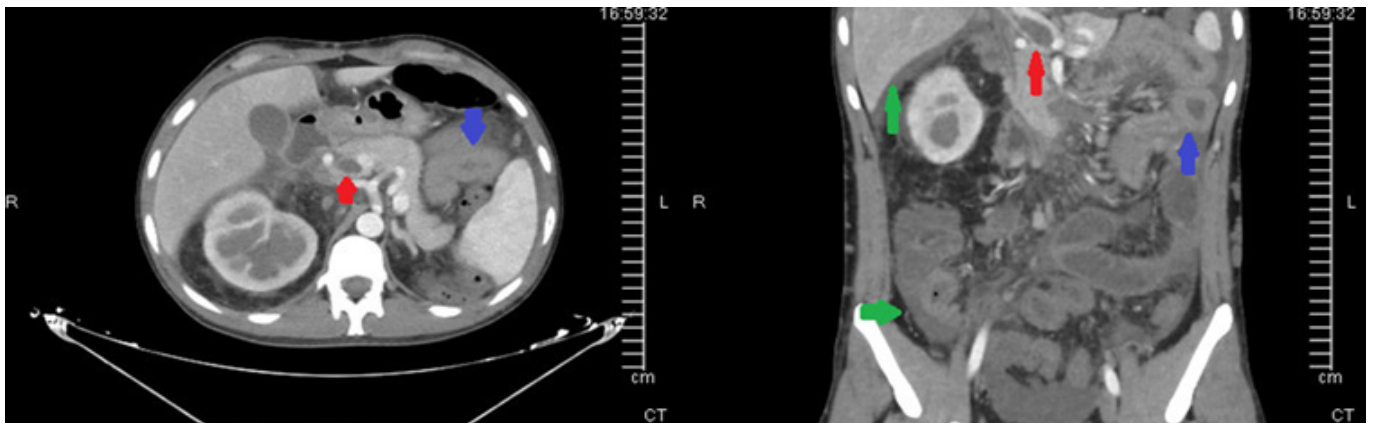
Portal venous phase CT shows thrombus in the SMV truncal segment (red arrow), edema and contrast uptake in the intestinal wall (blue arrow), minimal free fluid (green arrow)
